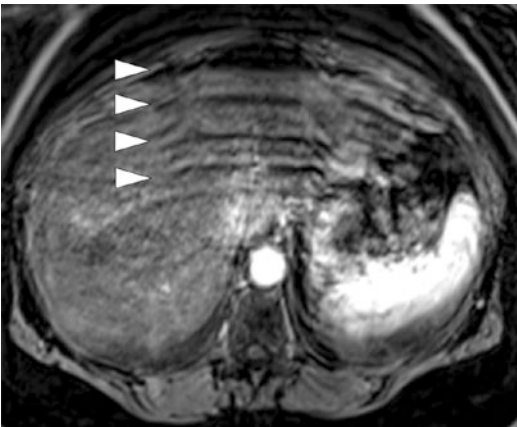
Axial post-enhancement fat-suppressed T1-weighted image demonstrating respiratory motion artifact, as is manifested by the striated appearance in the anteroposterior plane (arrowheads)
